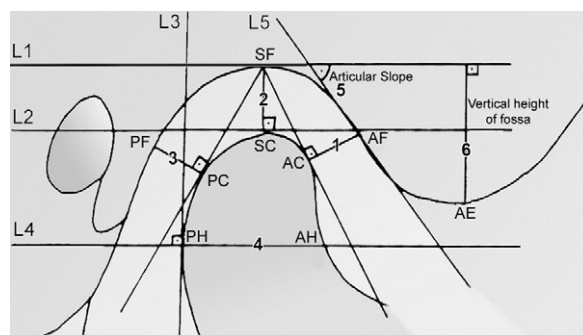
Linear and angular measurements of transcranial TMJ radiographs: 1, anterior joint space (AJS); 2, superior joint space (SJS); 3, posterior joint space (PJS); 4, condylar width (CW); 5, articular slope (AS); 6, vertical height of the fossa (VH).
